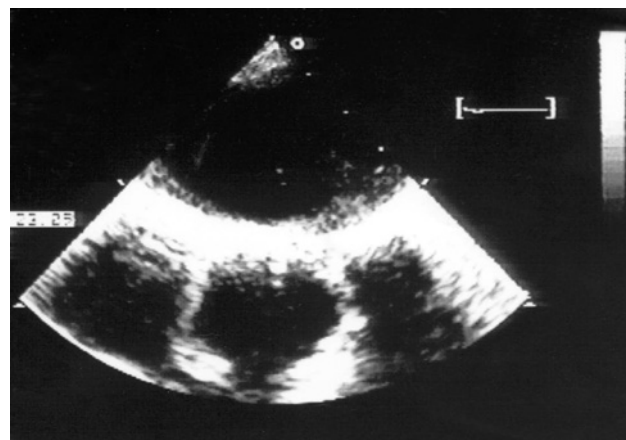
Epiaortic ultrasonography of patient 1.
